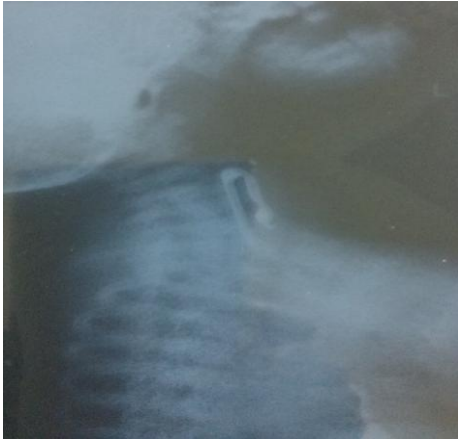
X-ray neck lateral view
